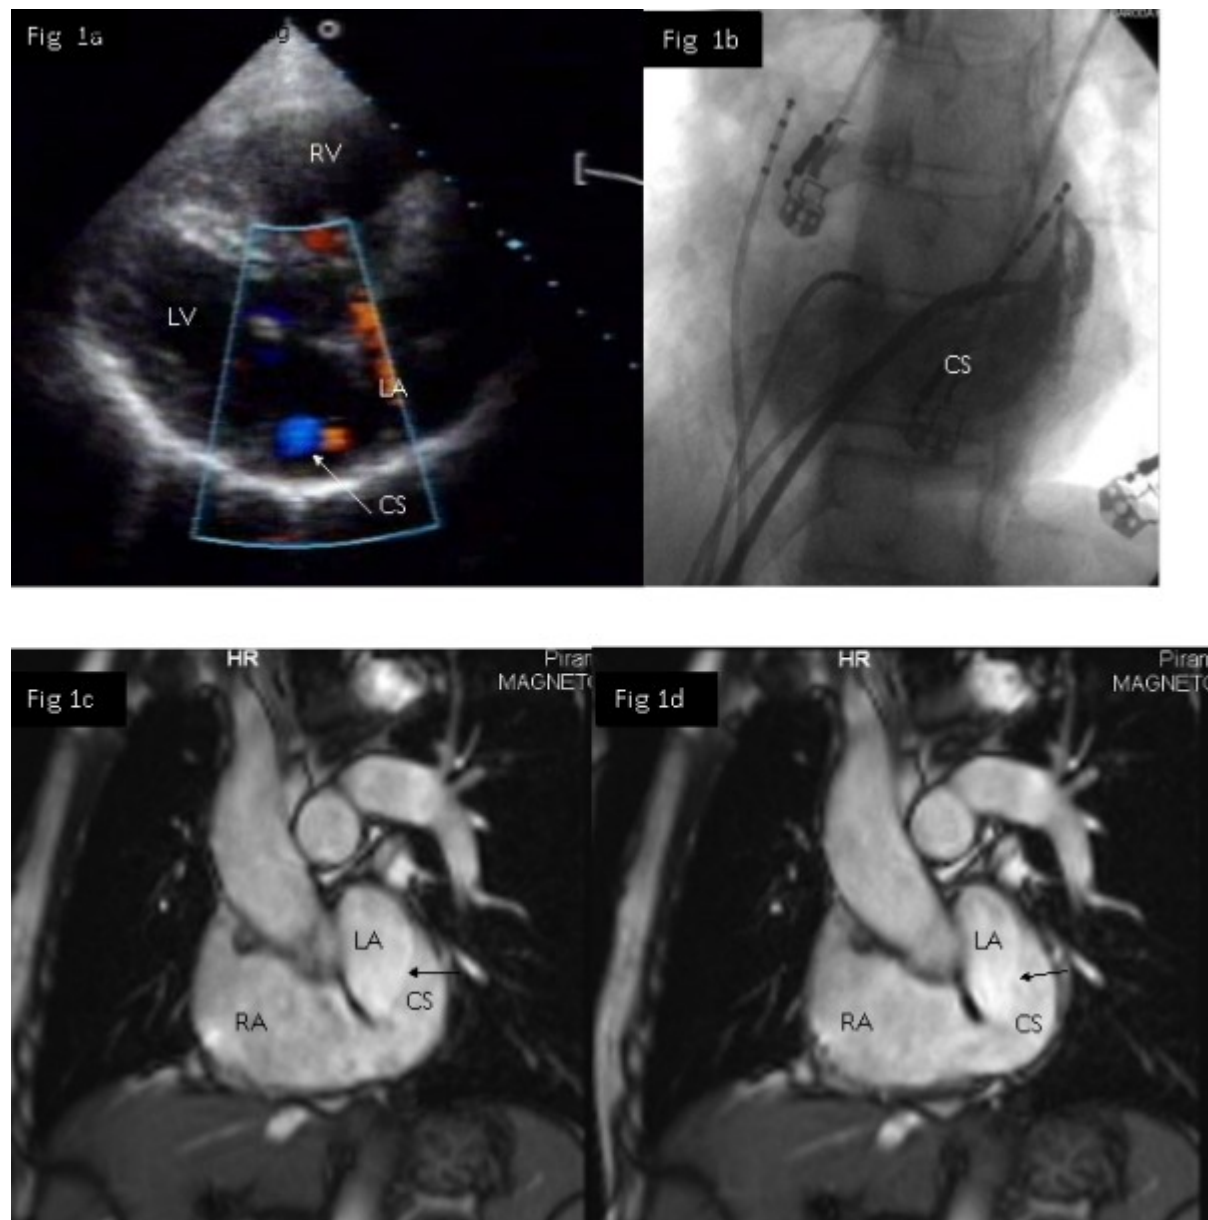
Dilated coronary sinus due to partial unroofing into left atrium. Figure 1a. Modified PLAX view on trans-thoracic echocardiography showed dilated coronary sinus with turbulence within it (marked with white arrow). Figure 1b. Coronary sinus angiography in LAO view showed a large coronary sinus opening with a wide mouth into the RA. Figure 1c. Cardiac MRI showing presence of large coronary sinus with clear differentiation between LA and CS in one of the planes (marked with black arrow). Figure 1d. Cardiac MRI showing presence of partial unroofed coronary sinus (marked with black arrow).
